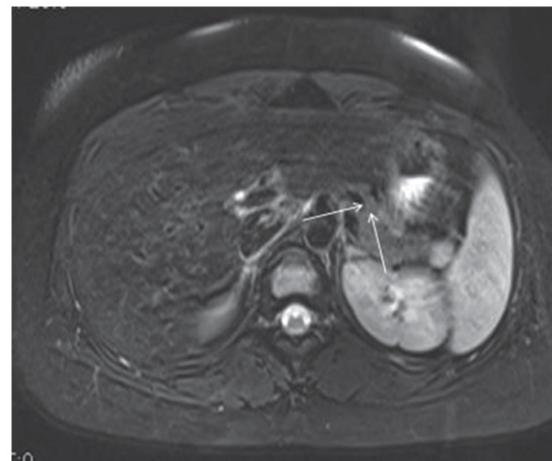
Isointense lesion on a T2-weighted axial magnetic resonance image (arrows).
